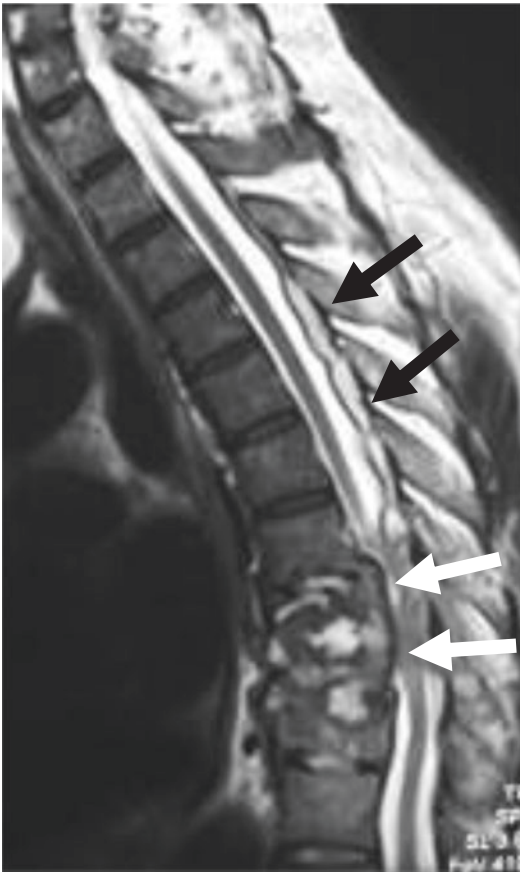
Fungal spondylodiscitis. Sagittal T2-W MR image shows gross destruction of T8, T9, T10, and T11 vertebral bodies and posterior elements with an epidural component (white arrows) and cranial tracking (black arrows)
